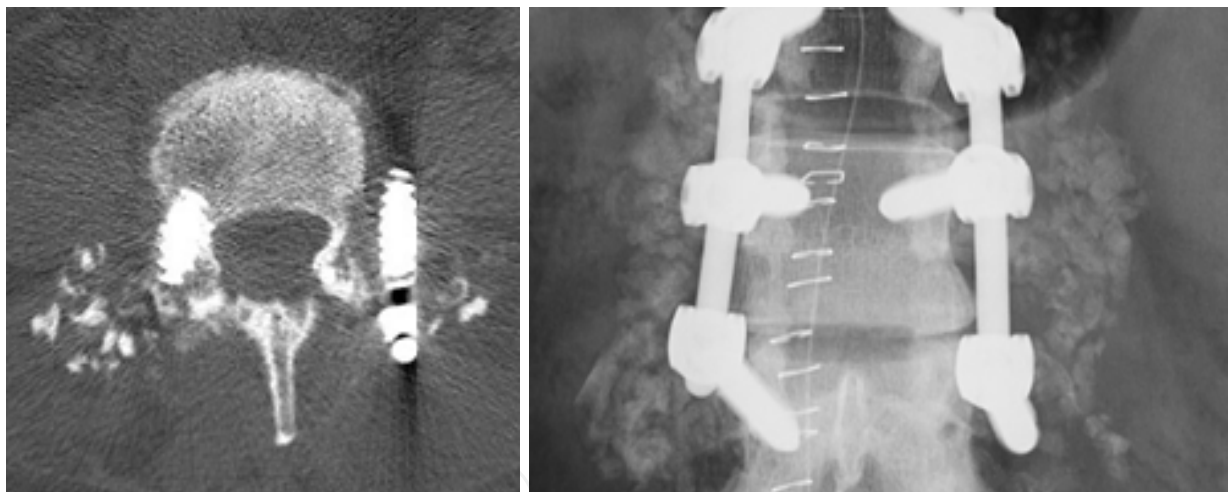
Radiographic and CT image showing the extrapedicular position of the screw.
